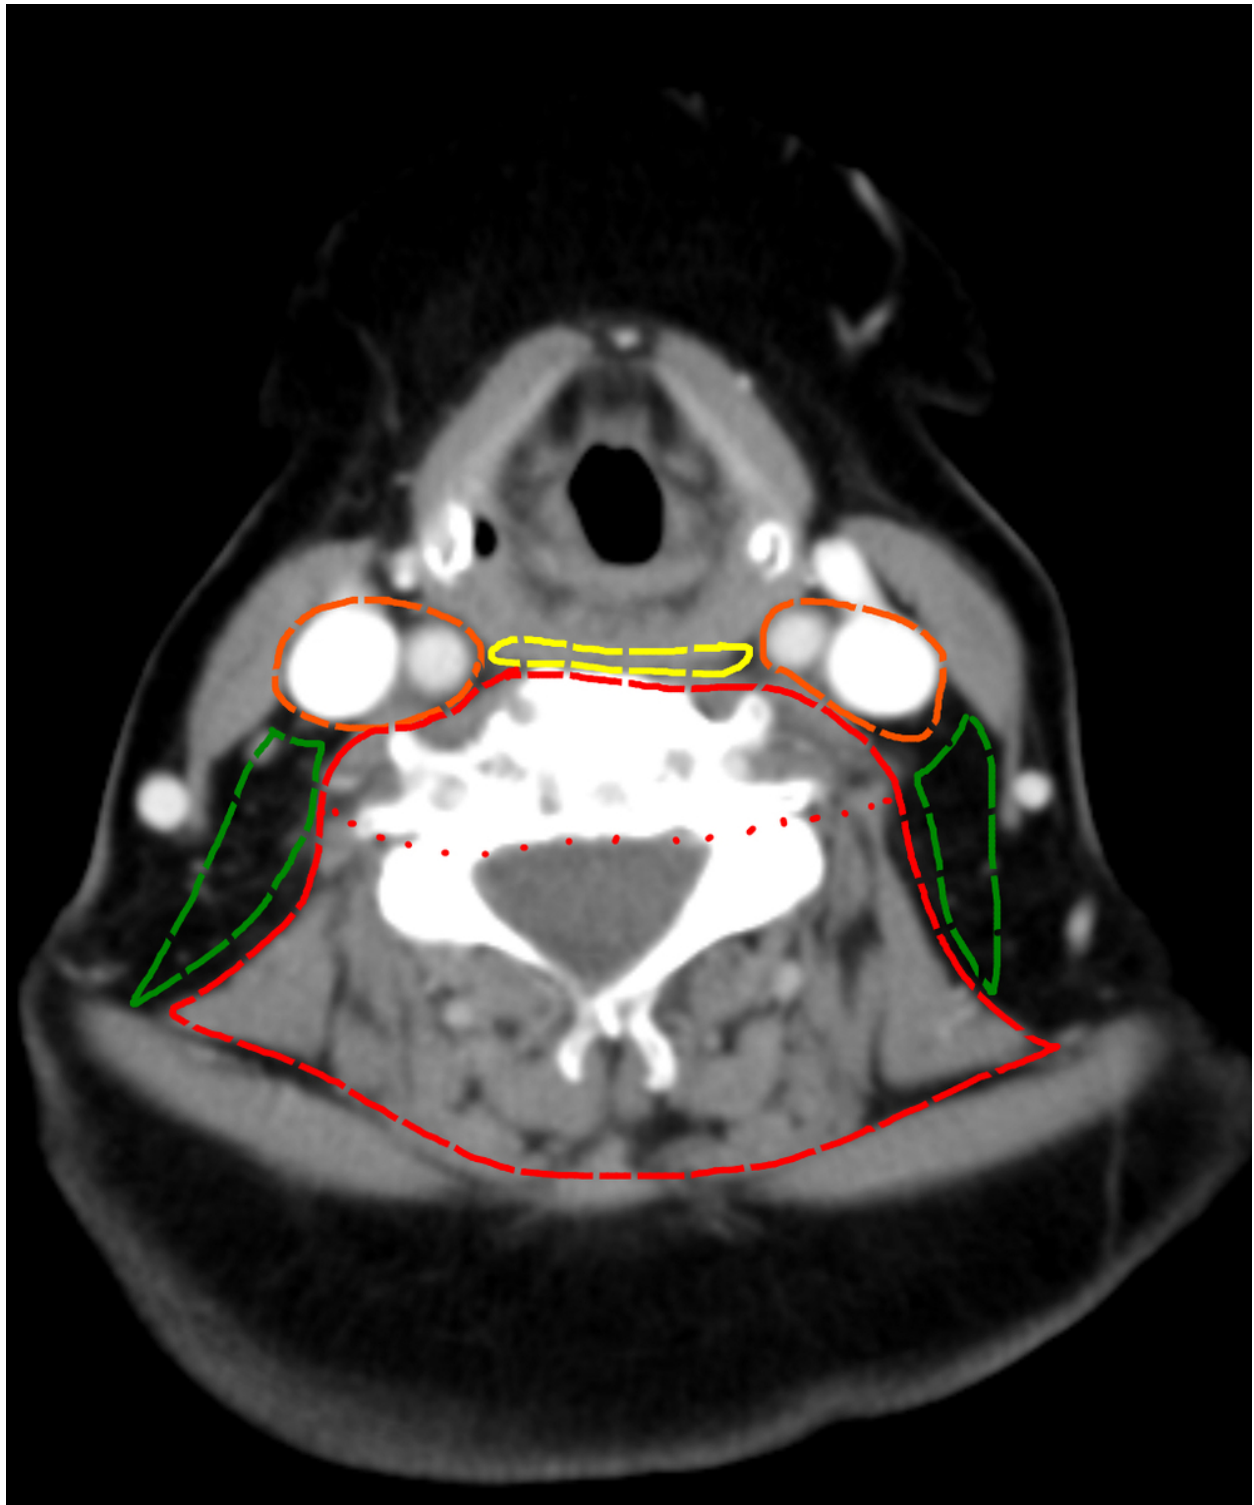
Contrast enhanced CT scan in the axial plan of suprahyoid region of the neck demonstrating carotid space (orange dash line), retropharyngeal space (yellow dash line), perivertebral space (red dash line) and cervical posterior space (green dash line).
